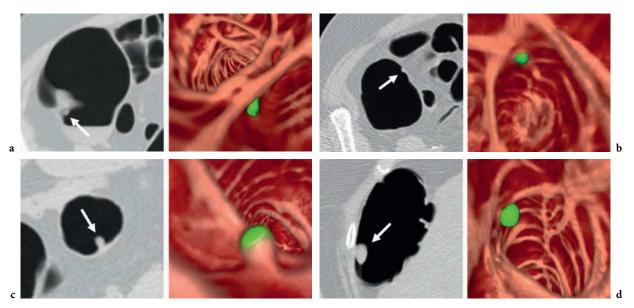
Example of polyps detected by CAD. For each pair, the left image shows an axial CT image containing a polyp, indicated by an *arrow*, and the right image shows its 3D endoluminal view by perspective volume rendering. The color coding is based on the shape index values (see Fig. 27.3, 27.4) (Näppi et al. 2005a), in which polyps, folds and the colonic wall are shown in green, pink and brown, respectively. a A 6-mm sessile polyp in the cecum and (b) a 5.3-mm polyp in the cecum. These polyps were missed by a radiologist at first reading. c A 7-mm polyp in the transverse colon, and (d) an 11-mm sessile polyp in the hepatic flexure. Polyps are clearly differentiated from folds and the colonic wall. Reprinted, with permission, from (Yoshida and Dachman 2005)
